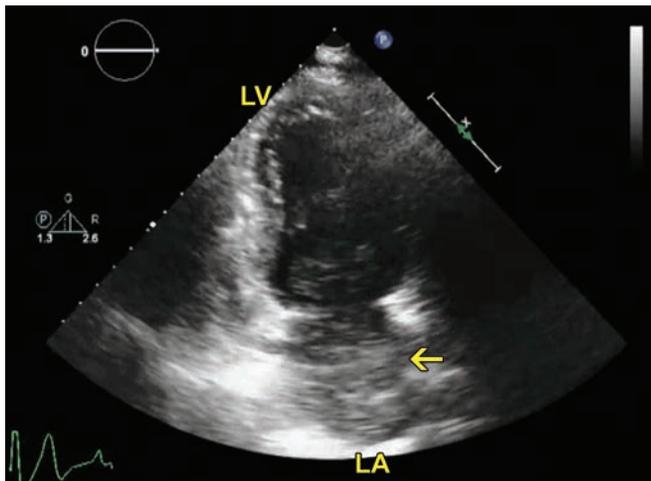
Transthoracic apical 2 chamber view with similar findings as above. Arrow points to the mass.
